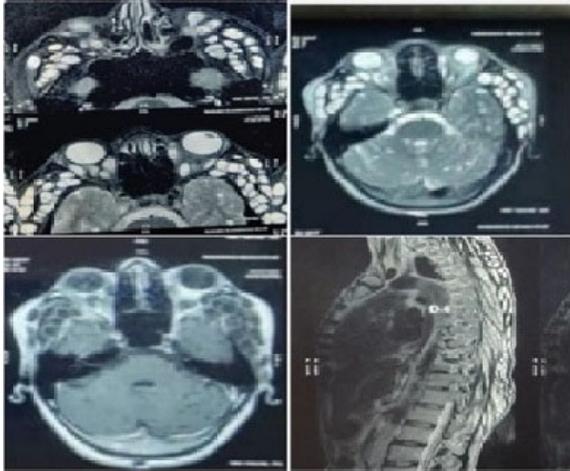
MRI brain with orbit & spine showing ocular cysticercosis with spinal and intracranial involvement
